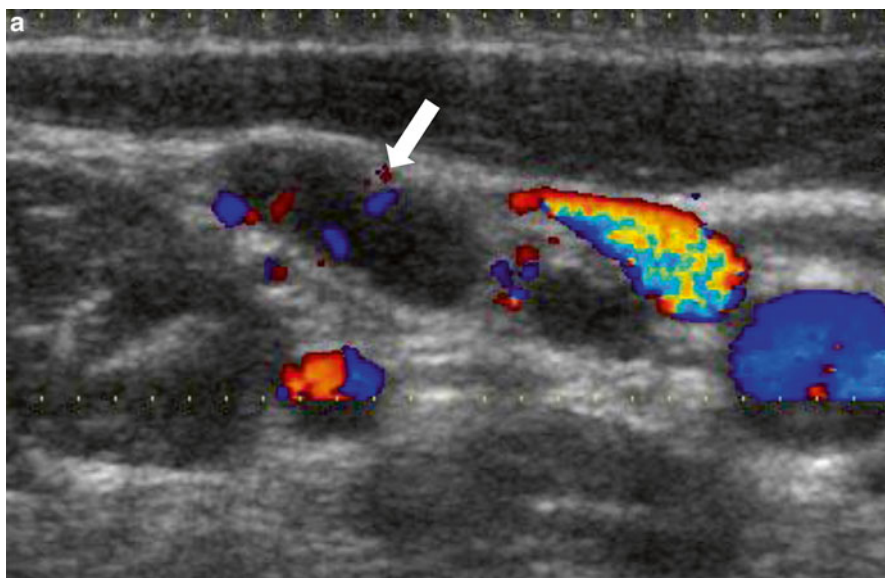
A 17-year-old female with a locally metastatic PTC presented for further evaluation at a tertiary cancer center after having already had two surgeries. Cervical ultrasonography revealed a suspicious, 1.3 cm right level IV lymph node (a, arrow), which was proven to be PTC after fine-needle aspiration biopsy. Despite the presence of residual lymph node disease, there was no indication of iodine-avid lateral neck metastases on a diagnostic ^{123}I thyroid scan (b). Preoperative contrast-enhanced CT also identified a suspicious lymph node in the right tracheoesophageal groove (c, arrow), which was resected and proven to be PTC. Subsequent to her third surgery, the patient had no evidence of residual PTC, and she remains disease-free greater than 4 years after her last surgery.
